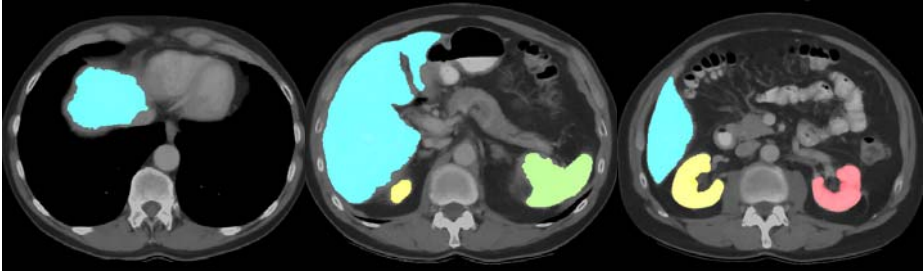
A typical example of liver (blue), spleen (green), right kidney (yellow) and left kidney (red) automated segmentation on 2D axial views of the CT data
